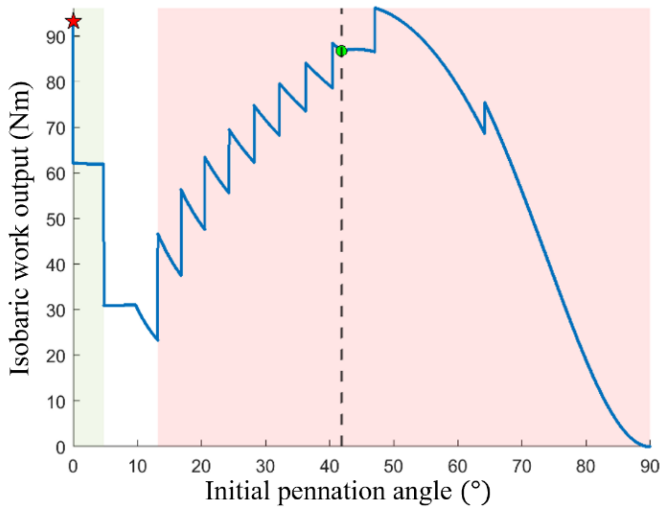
ISOBARIC WORK OUTPUT CAPACITY WITH RESPECT TO INITIAL PENNATION ANGLE
